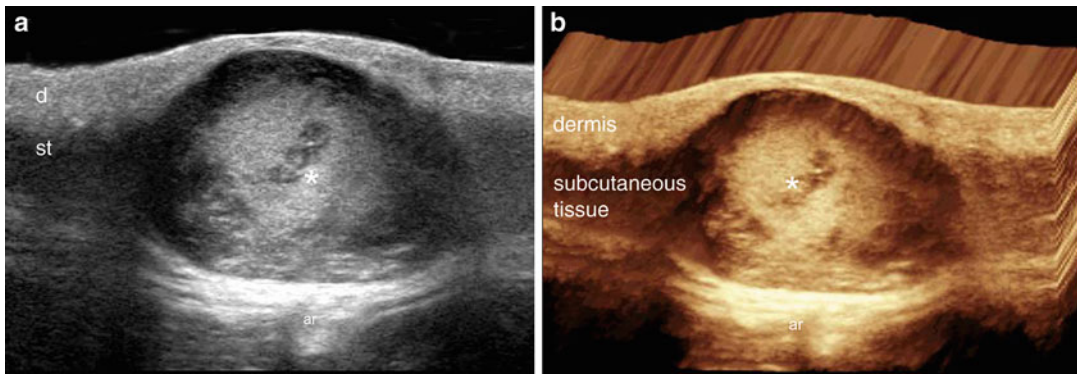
Epidermal cyst (longitudinal views, lumbar region). (a) Grayscale ultrasound shows a well-defined, oval-shaped hypoechoic structure (*) with posterior acoustic reinforcement
